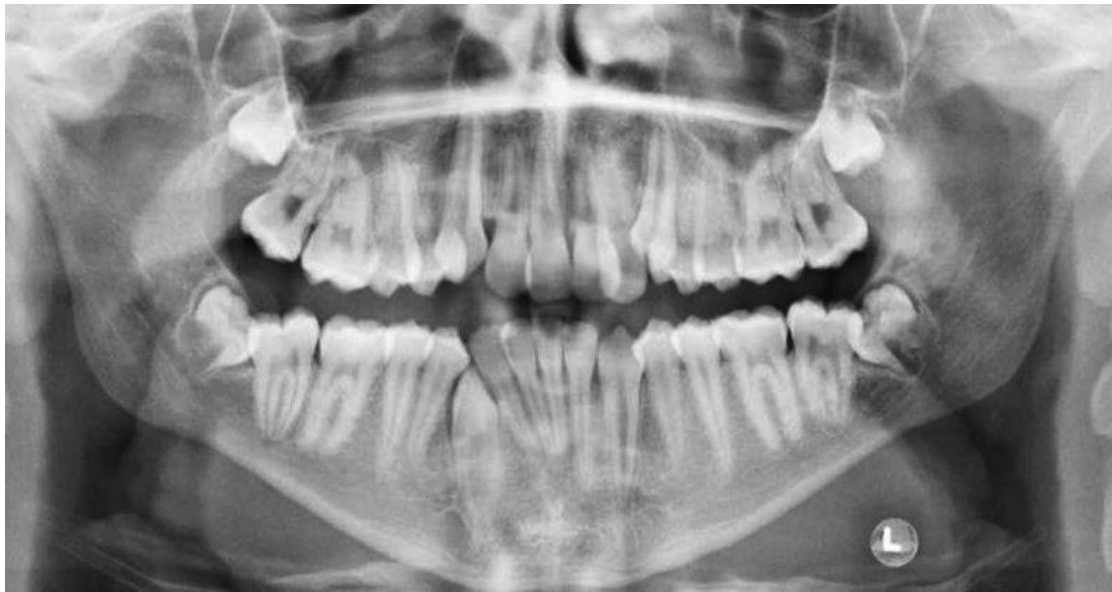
DPT radiograph showing distoangularly impacted lower second molars
